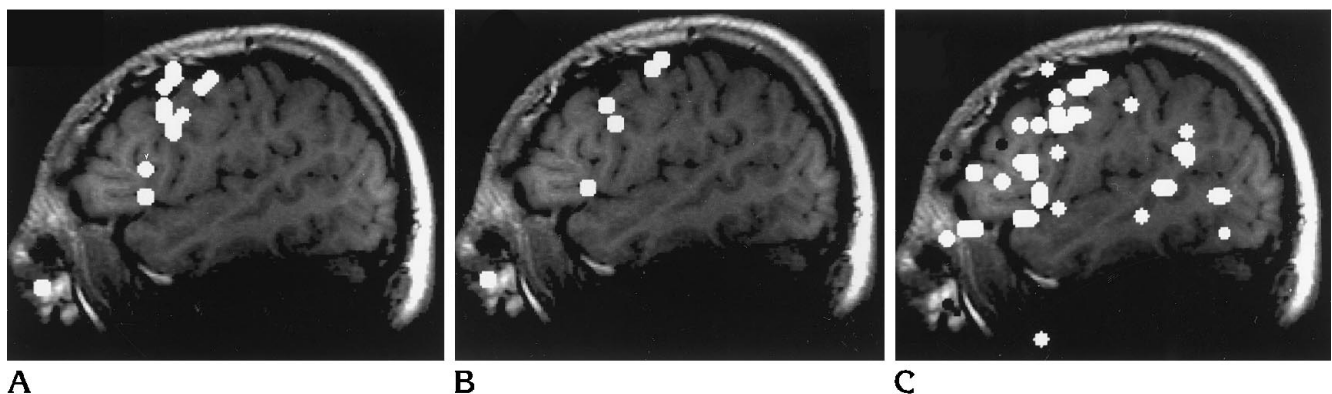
Functional MR images of a volunteer performing silent word generation in his native language (A), in a foreign language in which he is fluent (B), and in a language in which he is not fluent (C). Most of the activation is observed in prefrontal and frontoparietal regions. Note the increased number of activated pixels for the language in which the subject is not fluent (C).
